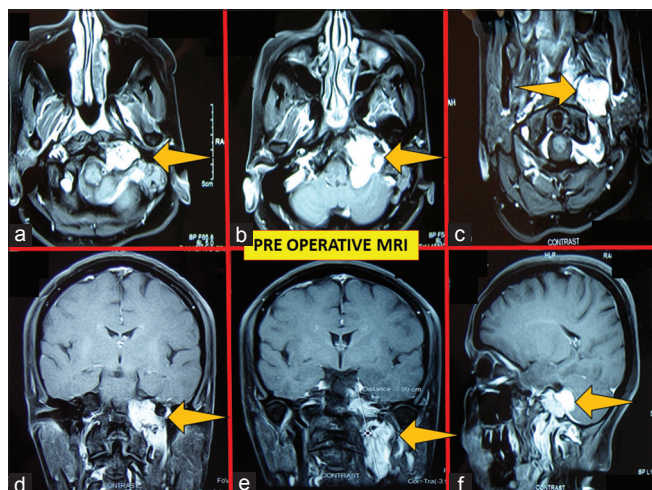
Preoperative contrast magnetic resonance imaging of patient 1: (a-c) are axial images, (d) and (e) are coronal, and (f) sagittal sections showing left glomus jugulare tumor (arrows)
